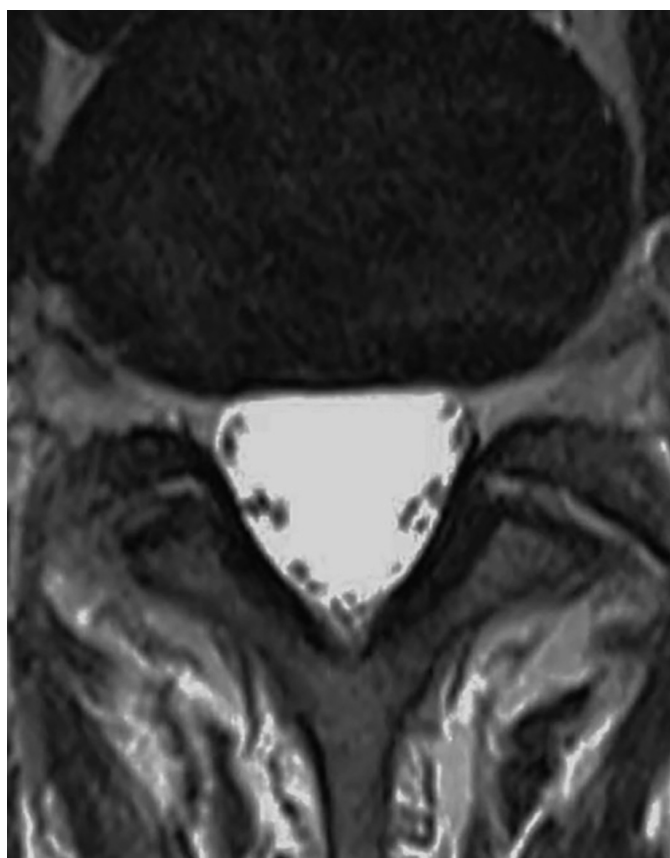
MRI image of the normal lumbar disc L4-L5.
